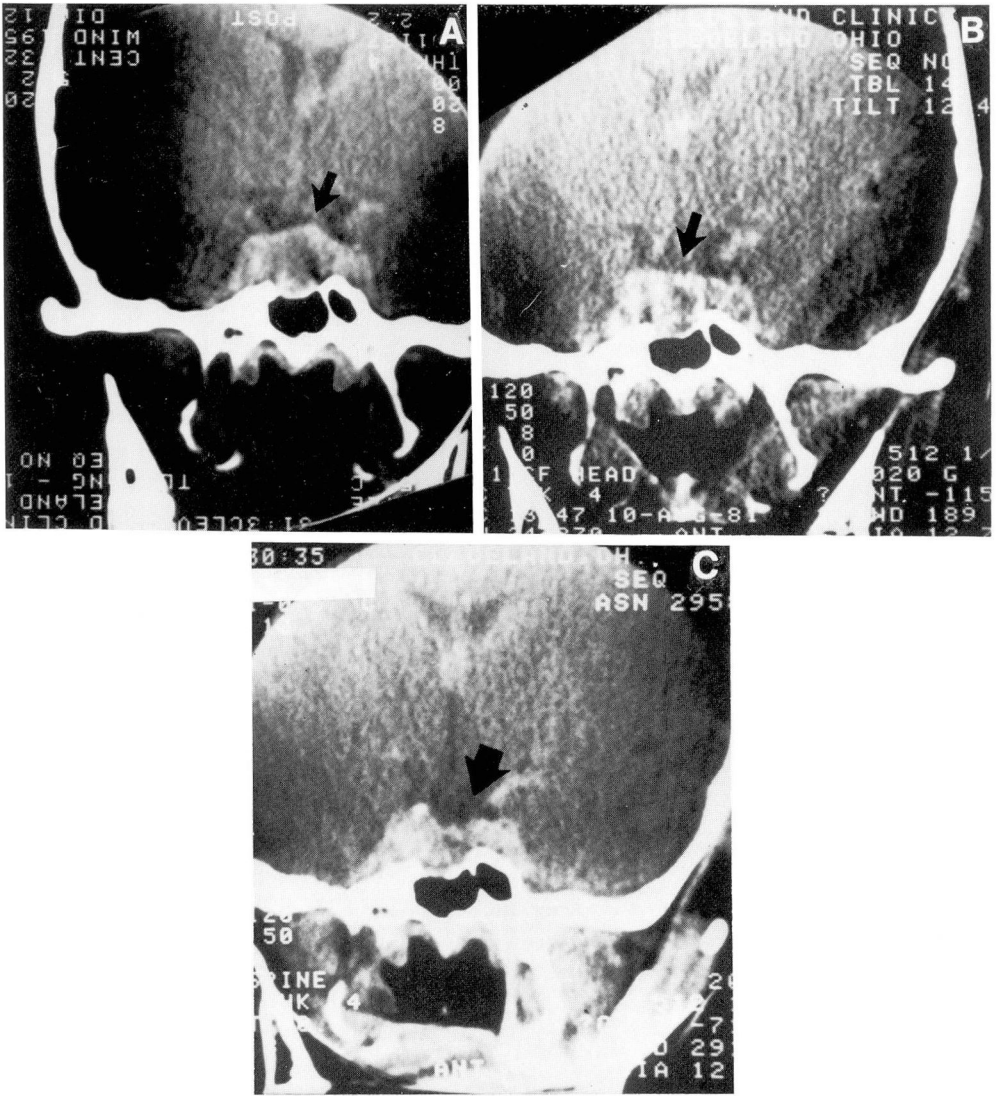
Sector CT scans of the sella turcica at 1, 2, and 3 years follow-up showing progressive decrease in size of the pituitary adenoma.
